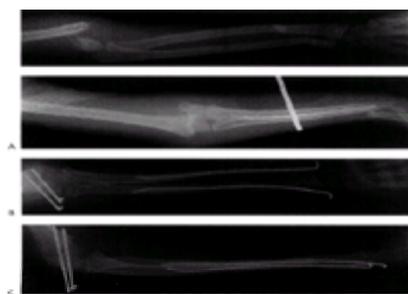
Displaced fractures of the radius and ulna associated with type III supracondylar fracture. A: Radiograph at time of presentation. No neurovascular deficits are noted. B and C: Flexible intramedullary wires were used to stabilize the forearm, with percutaneous pins to stabilize the humerus. This facilitates postoperative management during cast changes.
